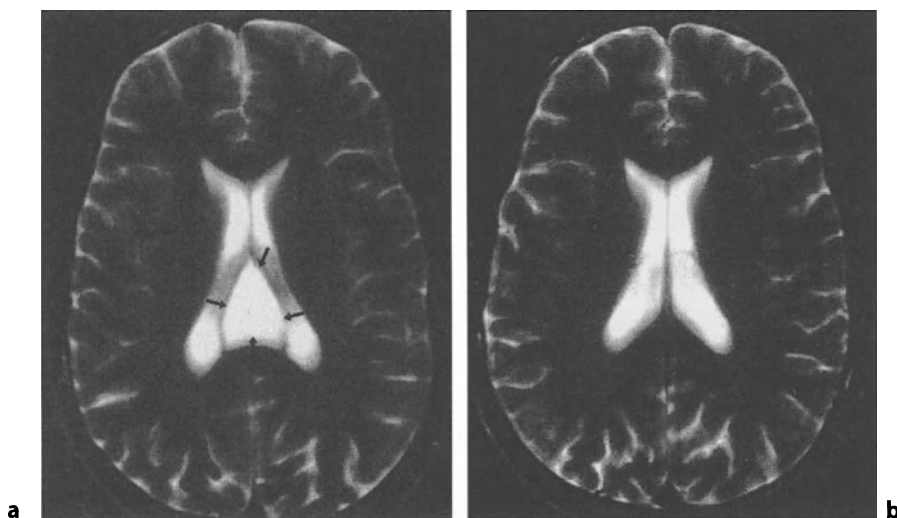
Magnetic resonance imaging (MRI) at the level of the lateral ventricles in two 26-year-old monozygotic twins. a Twin A:
